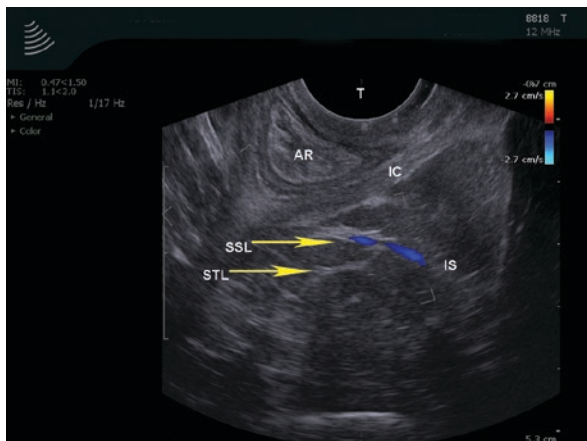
2D endovaginal view of the sacrospinous complex obtained with a BK triplane 8818 transducer (BK Ultrasound, Analogic, Peabody, MA, USA); the pudendal nerve which goes between the sacrospinous ligament and sacrotuberous ligament travels along the neurovascular bundle (*blue*). Transducer (T), anorectum (AR), iliococcygeus (IC), sacrospinous ligament (SSL), sacrotuberous ligament (STL), ischial spine (IS). (© Shobeiri)
